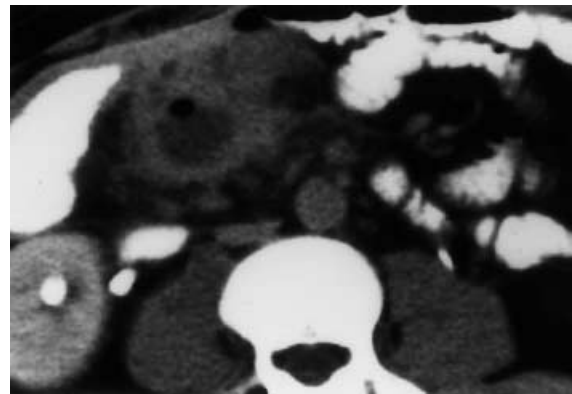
CT in a 42-year-old man with Crohn's disease and a loop abscess
